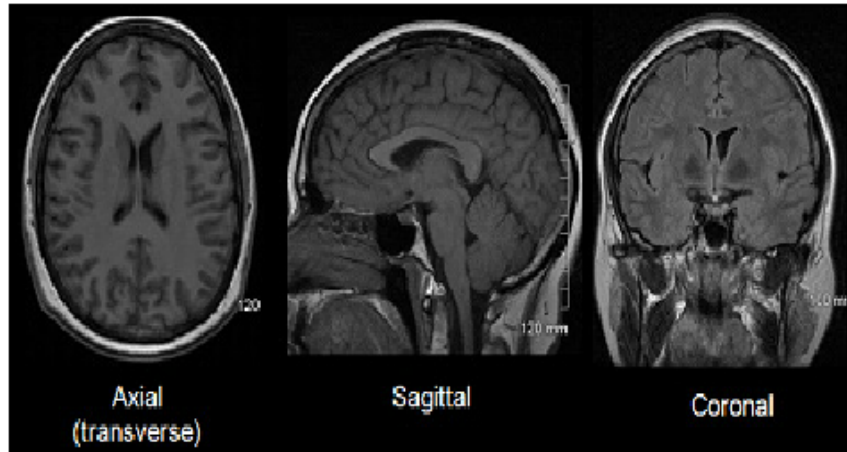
Different planes of MRI brain image [7]
